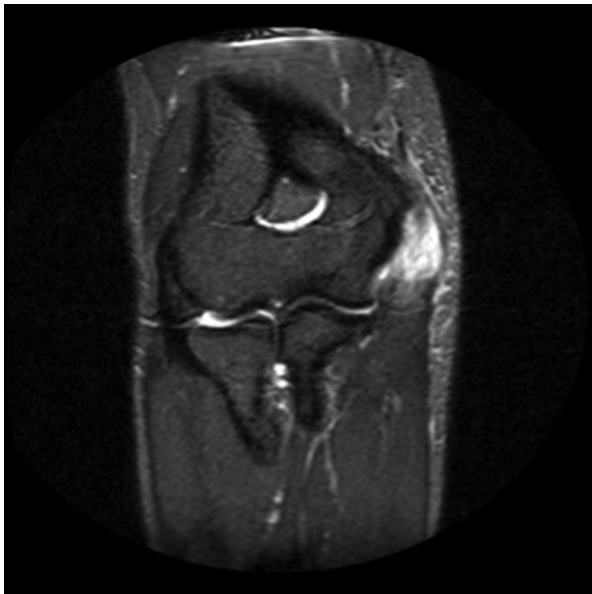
Representative coronal T2 magnetic resonance image of a patient with medial epicondylitis. Greatest signal intensity near the flexor-pronator origin indicates tearing of the tendon.
